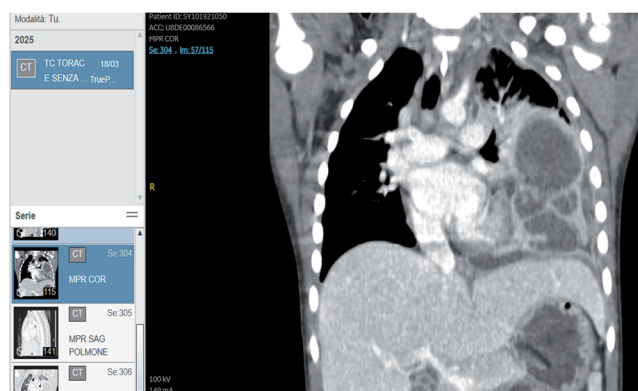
Chest CT: Left lung largely occupied by multiple fluid-filled collections. The largest, measuring 62 x 41 x 69 mm, also contains an air component and is located in the posterior half of the upper two-thirds of the left lung (abscesses).
